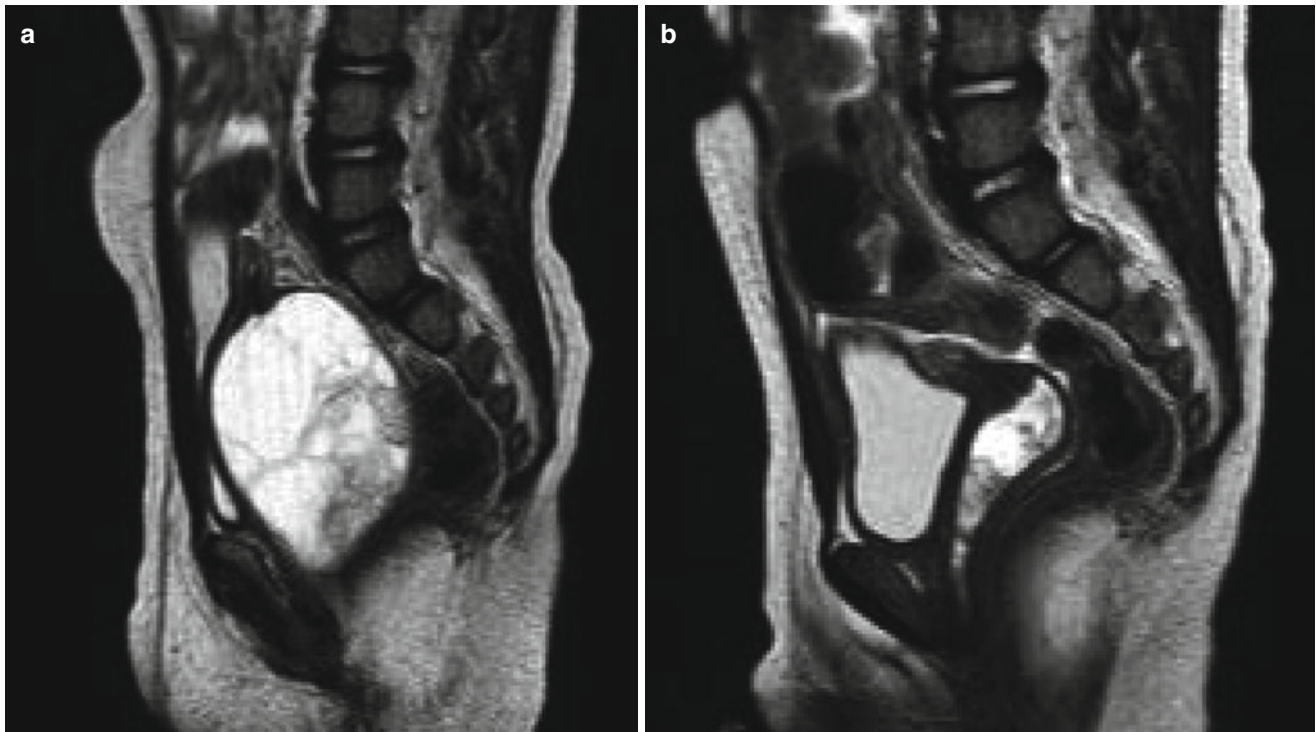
(a) Vaginal RMS at diagnosis (Sagittal T2 weighted MRI). (b) After 6 courses of chemotherapy, persistent vaginal tumour with multifocal implantation
